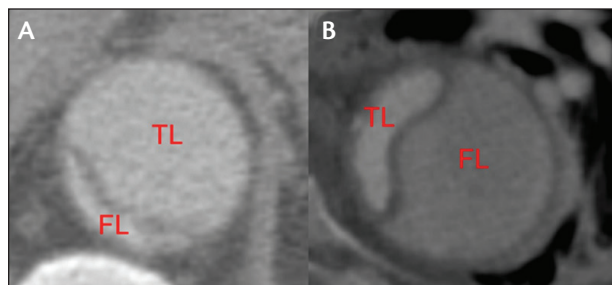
Computed tomography images show the configuration of the TL and FL. A circular-shaped TL is shown (A). An elliptic shape results when the FL compresses the TL (B). Adapted from *J Vasc Surg*, Volume 58, Tolenaar et al, Morphologic predictors of aortic dilatation in type B aortic dissection, pages 1220-1225, Copyright 2013, with permission from Elsevier.¹⁷
